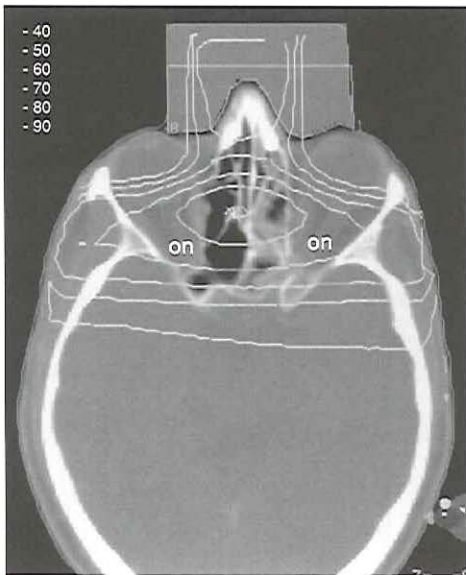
Isodose distribution in Gy on a transversal CT plot at the level of the optic nerves (on) with the summed 3D dose data of the lateral opposed 4 MV photon fields (70 Gy) and an anterior 16 MeV electron field (46 Gy). The asterisk indicates a maximum dose of 91.4 Gy.
